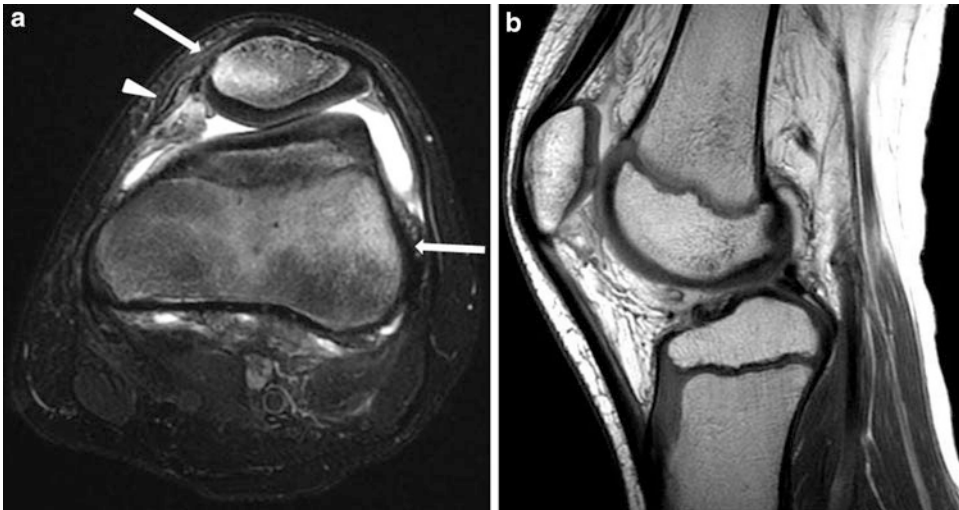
(a, b) A 12-year-old boy with history of right transient patellar dislocation 2 years ago presented with *left* knee pain after an injury 4 weeks ago. MRI image (a) showed classic findings of transient patellar dislocation. There is subchondral marrow edema in the medial patella
